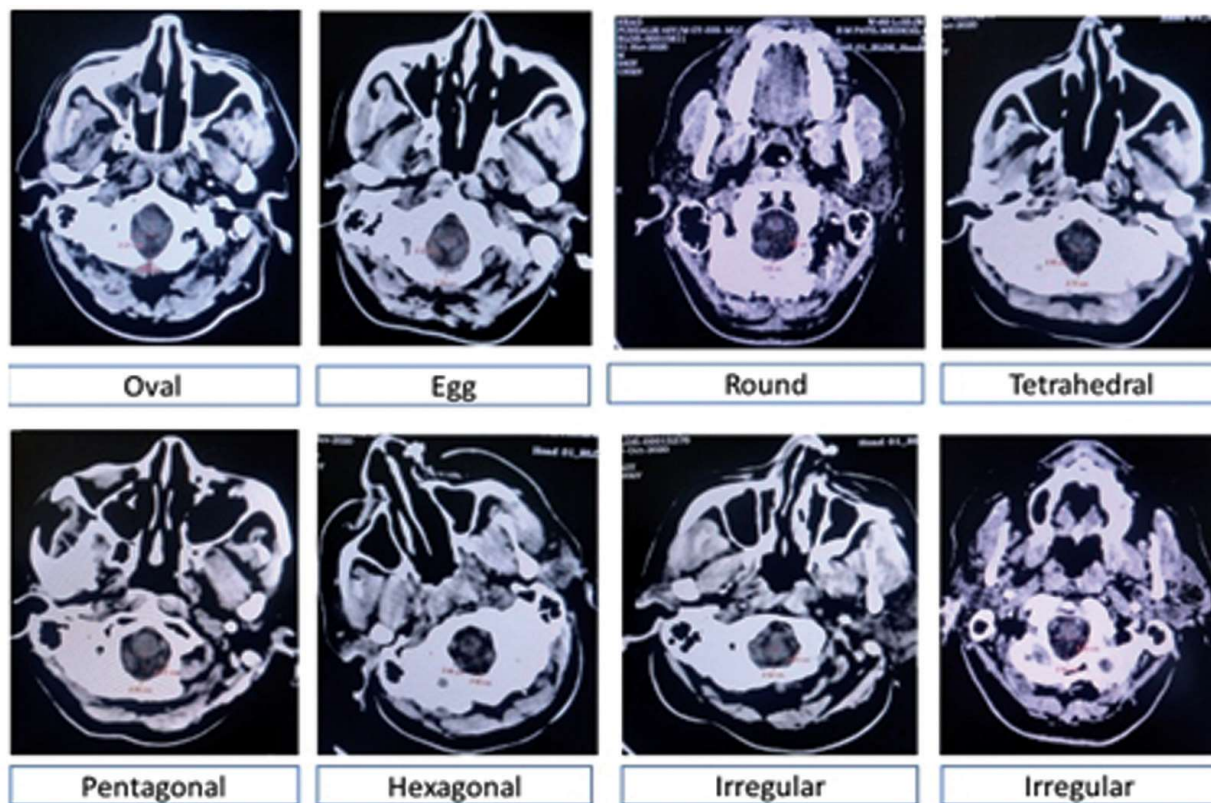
Different shapes of foramen magnum as studied in CT scans
